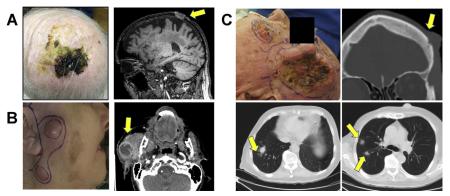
Examples of patients with advanced CSCC. (*A*) Patient with advanced scalp squamous cancer, with evidence of bone invasion through the calvarium on T1 contrast MR imaging (*arrow*). (*B*) Patient with advanced regional metastasis to the parotid gland (*arrow*), on CT imaging with contrast, and upper neck lymph nodes. This patient presented with facial nerve paralysis consistent with clinical perineural invasion. (*C*) Patient with a left temple squamous cancer recurrent after surgery and radiation. Left temple exhibited minor bone invasion (*right upper panel [arrow*]). He developed pulmonary metastases in the right lung, noted as spiculated lesions on CT imaging (*lower panels [arrows*]).
